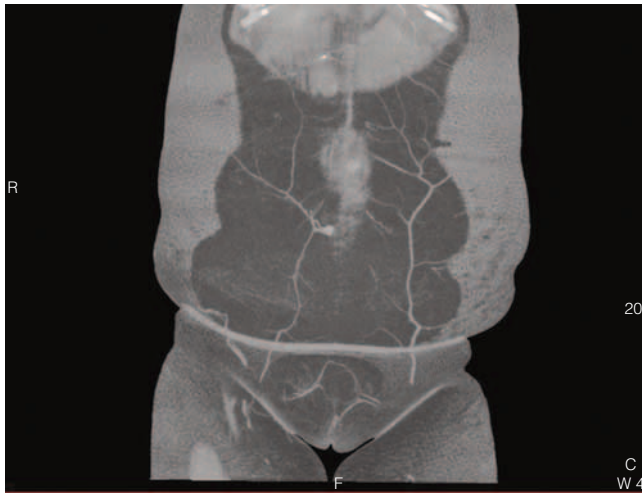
Preoperative computed tomographic angiography of the inferior epigastric arterial system, the basis for free transverse rectus abdominis myocutaneous (TRAM), deep inferior epigastric perforator (DIEP), and superficial inferior epigastric artery (SIEA) flaps, used for autologous breast reconstruction.
